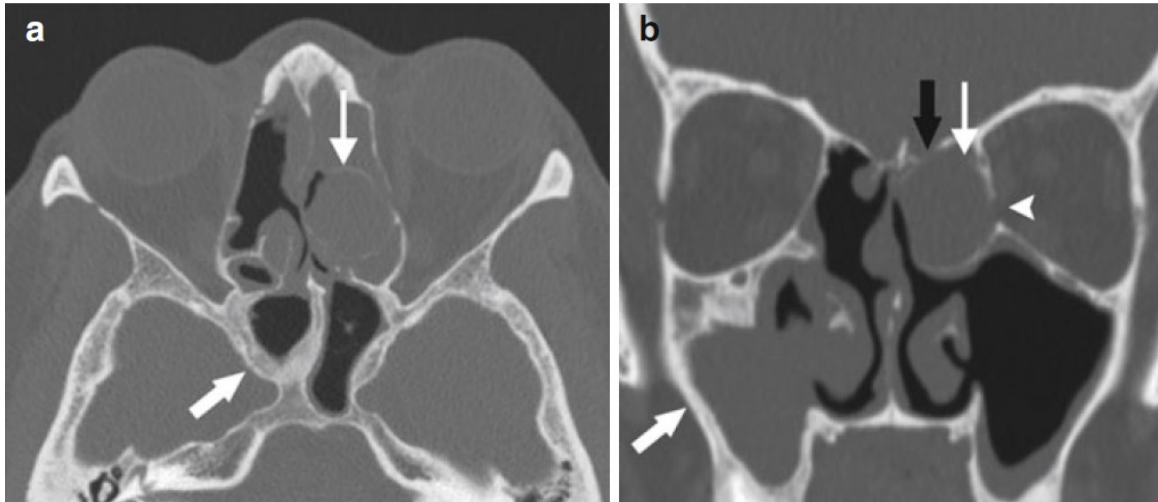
Bony changes with chronic sinusitis. Axial (a) and coronal (b) images of a patient with recurrent chronic sinusitis after endoscopic sinus surgery, with thickening and sclerosis surrounding chronic sinusitis within the sphenoid and the right greater than the left maxillary sinuses (*thick arrows*), as well as bony remodeling and expansion surrounding an opacified left ethmoid air cell, compatible with mucocoele (*thin arrow*). Note the thinning and dehiscence of the left lateral lamella (*black arrow*) and the left lamina papyracea (*arrowhead*) from the expansion of the mucocoele. Flanagan CE, Baugnon KL, DelGaudio JM. Radiographic Diagnosis of Chronic Rhinosinusitis. In: Batra PS, Han JK, eds. Practical Medical and Surgical Management of Chronic Rhinosinusitis. Cham: Springer International Publishing 2015:43-72.
